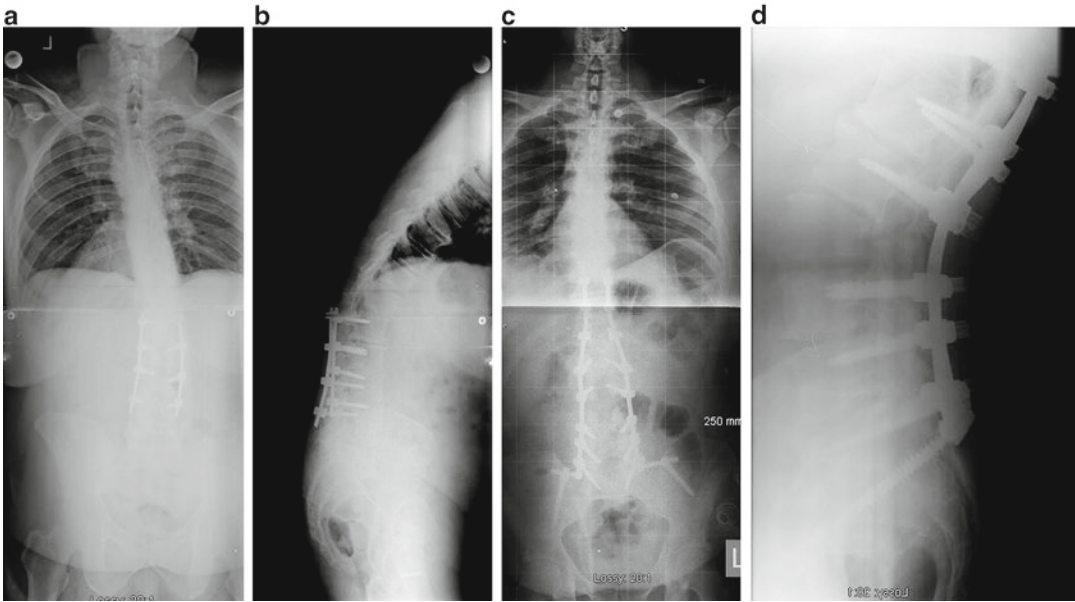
Case example of pedicle subtraction osteotomy. (a) Standing AP 36-inch scoliosis x-ray of patient with prior L2–L5 posterior fusion. (b) Standing lateral 36-inch scoliosis x-ray demonstrates sagittal imbalance with angular kyphosis above prior fusion. (c) Standing
